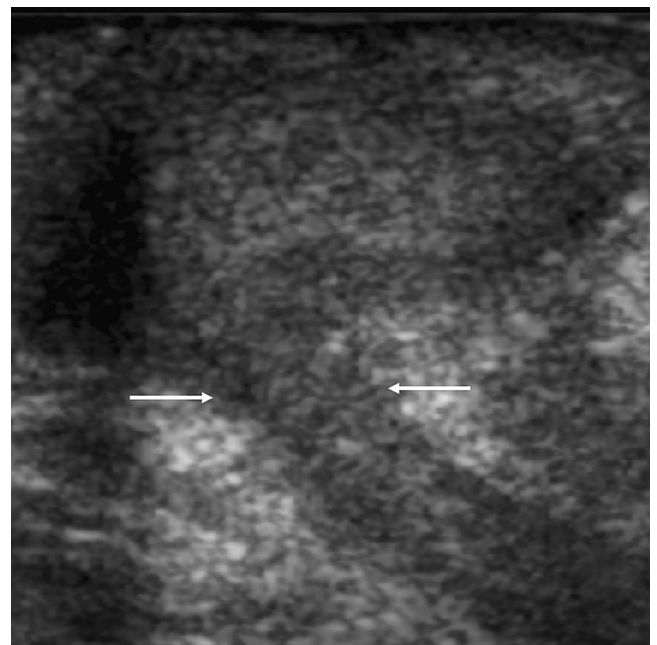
Fistulation to abdominal wall. This patient had longstanding Crohn disease that predominantly affected the small bowel. There is a fistula tract (arrows) that connects from the small bowel to the abscess (arrowheads) in the abdominal wall in this transverse sonography.
